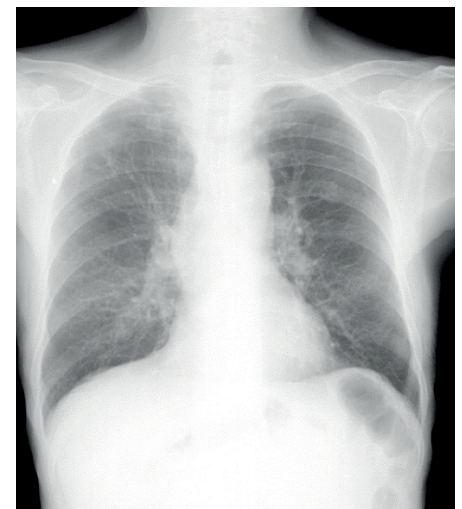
Chest X-ray image (original image).
